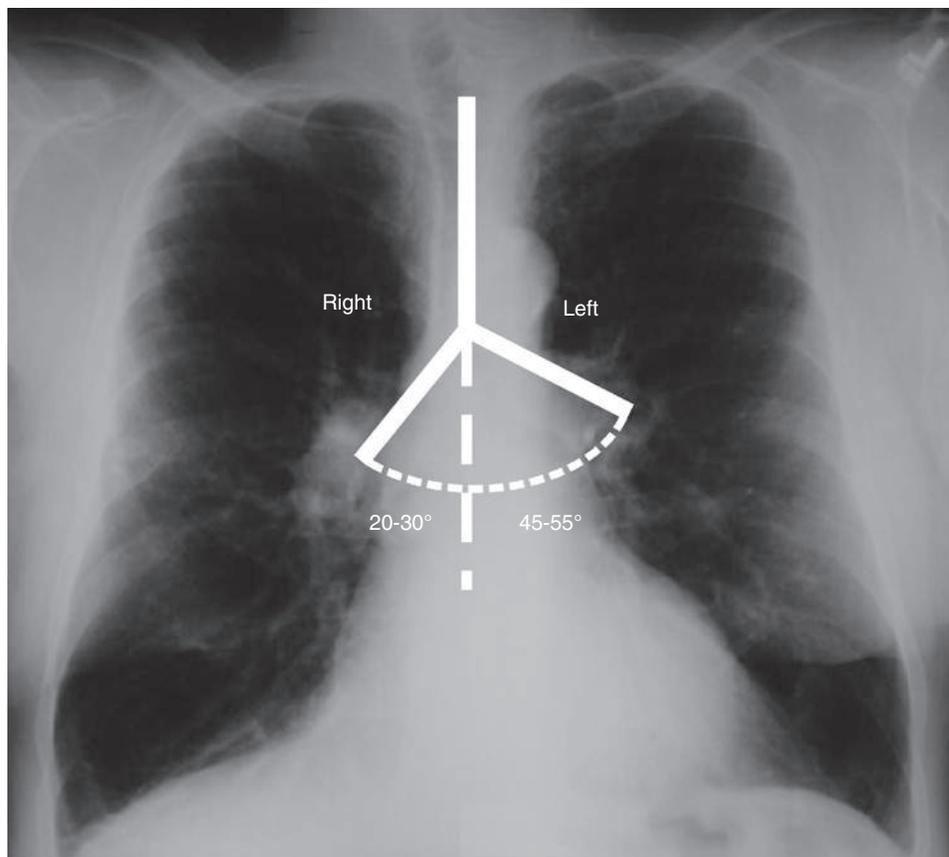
Course of trachea and right and left main stem bronchi, superimposed on a standard chest radiograph. The right main stem bronchus continues on a straighter course from midline than the left main stem bronchus.
